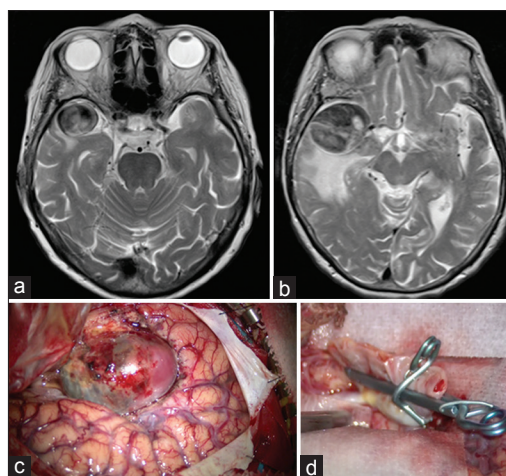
(a and b) Axial T2-weighted MR images showing an increase of the right middle cerebral artery aneurysm diameter from 2.5 to 4 cm in 2 years. (c) Intraoperative photograph of the aneurysm. (d) The aneurysm was clipped using two clips
